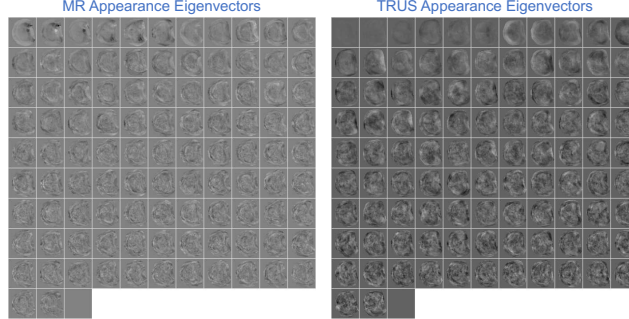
Sample eigenvectors showing joint MRI-TRUS intensity appearance found using PCA. The joint eigenvector is the concatenation of the MRI eigenvector and the TRUS eigenvector at the same positions in the two corresponding matrices. The first principal component with the largest eigenvalue is shown in the top left corner and the remaining principal components are sorted in decreasing order of their eigenvalues from left to right and top to bottom.
